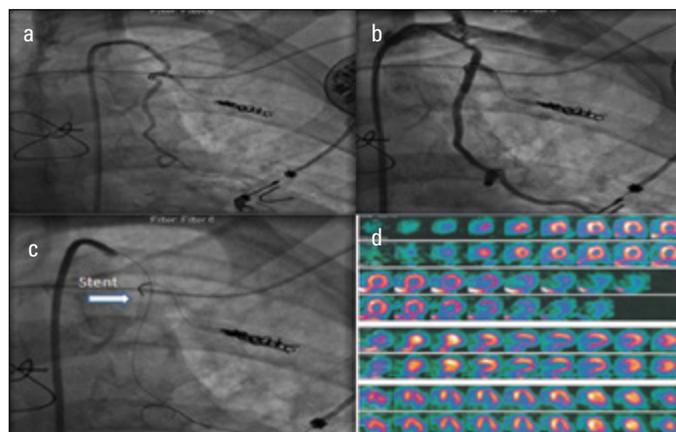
a-d. Detachment of the proximal part of the coil attachment apparatus (a), implantation of drug-eluting stent (b), cessation of the side branch of the left internal mammary artery flow (c), disappearance of ischemia following coil occlusion on myocardial scintigraphy (d)
